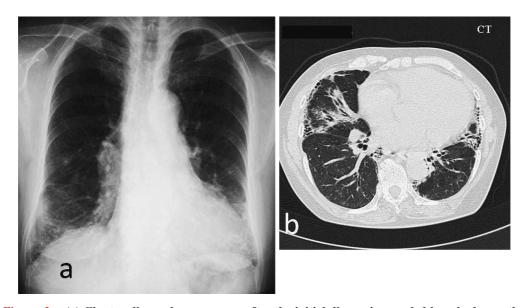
(a) Chest radiograph seven years after the initial diagnosis revealed lymphadenopathy as shown in the initial diagnosis. (b) Chest CT seven years after initial diagnosis showed that the slightly advanced pulmonary fibrosis had progressed.
